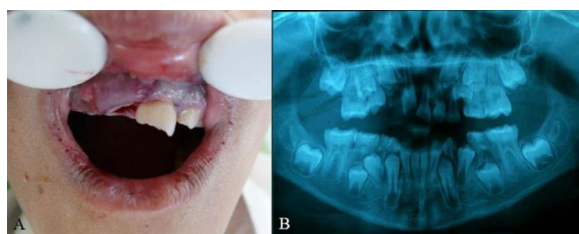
A) Photograph taken in the first appointment; B) Orthopantomograph taken in the first session
